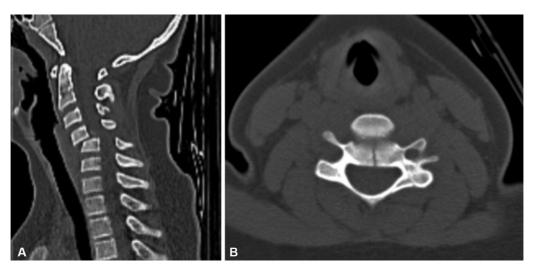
Preoperative images. (A) Sagittal computed tomography (CT) scan showing complete C4-C5 dislocation. (B) Axial CT scan showing a median fracture in the C4 vertebral body.
